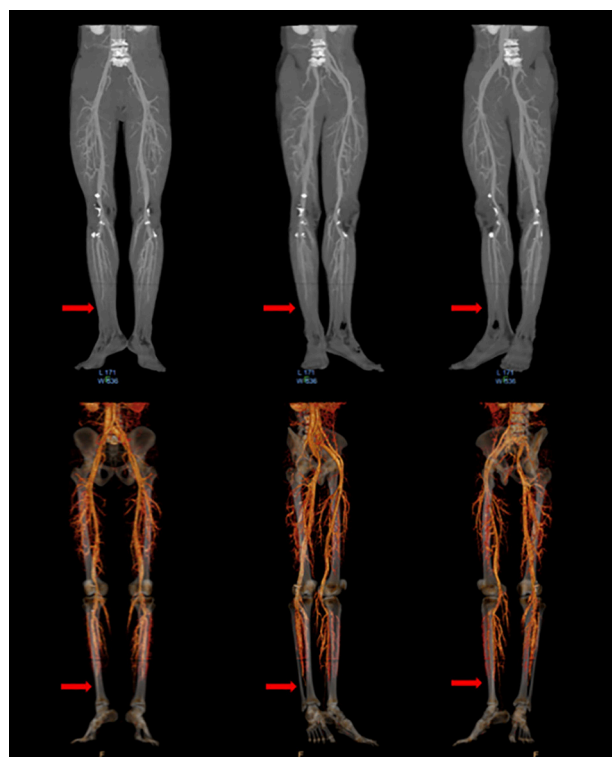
CT angiography of the lower limbs showing filling defects. The red arrow indicates the level of arterial occlusion.
